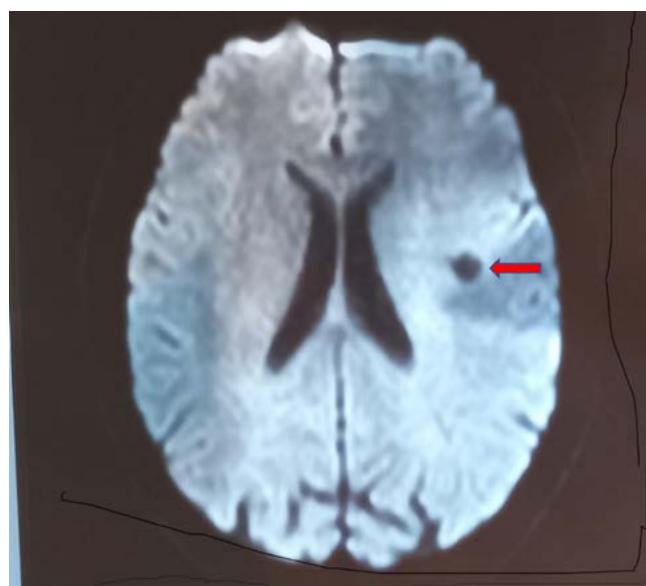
Patient neuroimaging CT scan showing a solitary cystic lesion (arrowed) in the left parietal region; this finding is characteristic of NCC
